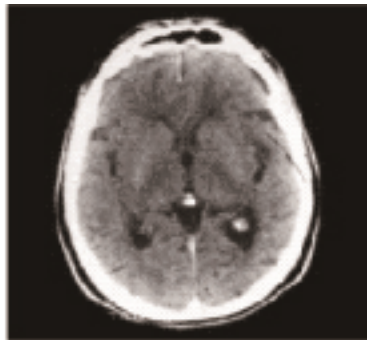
Transaxial brain image from CT
